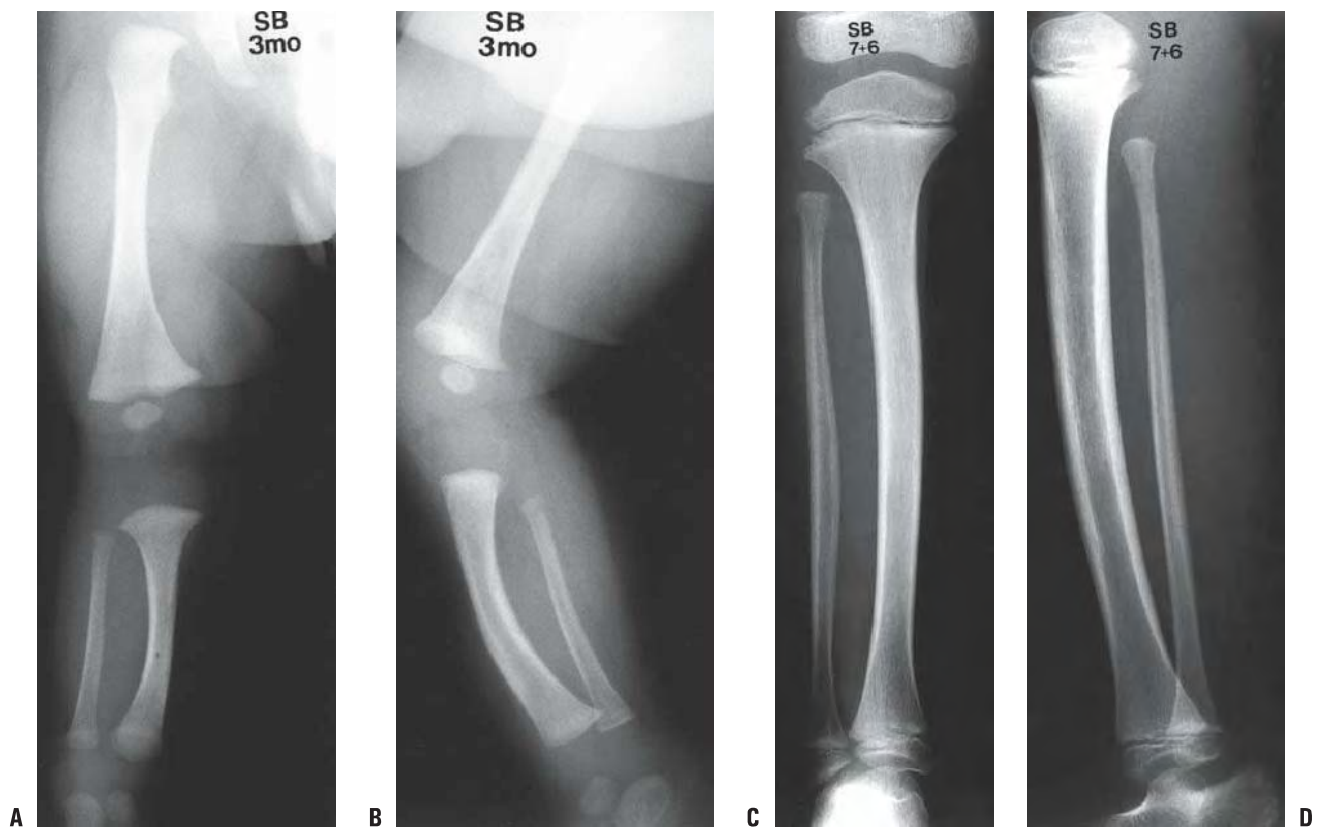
A,B: The radiographs of a 3-month-old boy with type 1a fibular deficiency of the Achterman and Kalamchi classification. The proximal fibula is short. C,D: AP and lateral radiographs of the same patient at the age of 7 years, 6 months. The shortening of the fibula is more apparent and the ball-and-socket ankle joint is easily seen. E: The foot at the same age, with the lateral two rays missing. F: At 13 years of age, the leg was lengthened by 7 cm.
